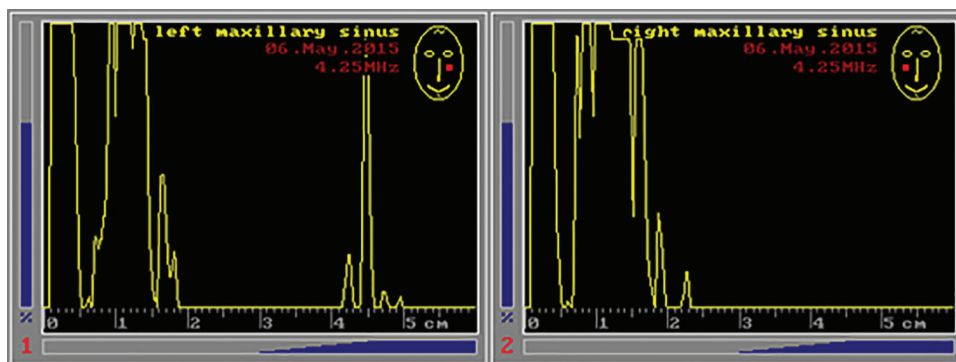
Interpretation of sinus ultrasound. In this example, A-mode ultrasonography was performed over bilateral maxillary sinus. The result of sinus ultrasound of left maxillary sinus was positive, presenting a back wall echo with distance ≥ 3.5 cm. On the contrary, the result of right maxillary sinus was negative.
